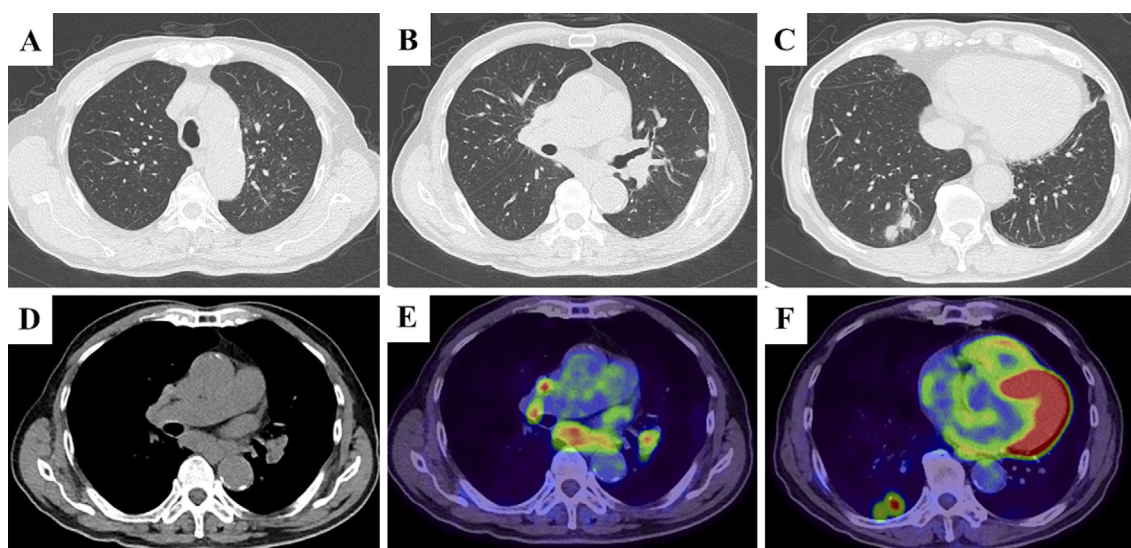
A computed tomography (CT) scan revealed multiple pulmonary nodules in both lungs, ground-glass opacities in the left upper lung (A-C), and bilateral hilar and mediastinal lymphadenopathies (D). A fluorodeoxyglucose positron emission tomography (FDG)/CT scan revealed multiple lesions with a high FDG uptake, pulmonary nodules, and hilar and mediastinal lymphadenopathies (E, F).
